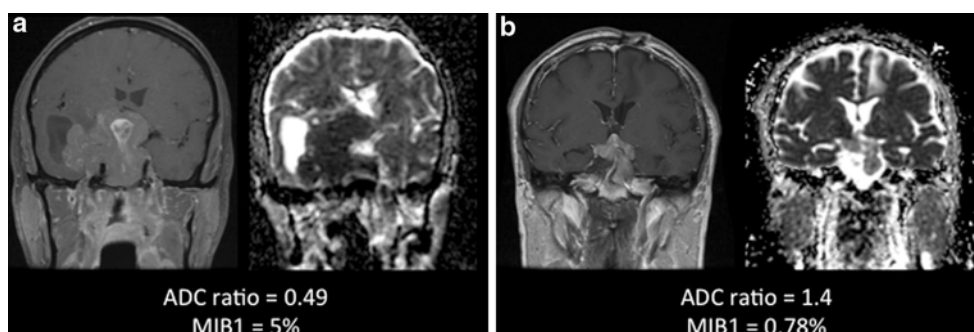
Apparent diffusion coefficient (ADC) maps and T1 post contrast MR images of invasive pituitary macroadenomas (a, b). The ADC values differentiate the two invasive adenomas, with low ADC
